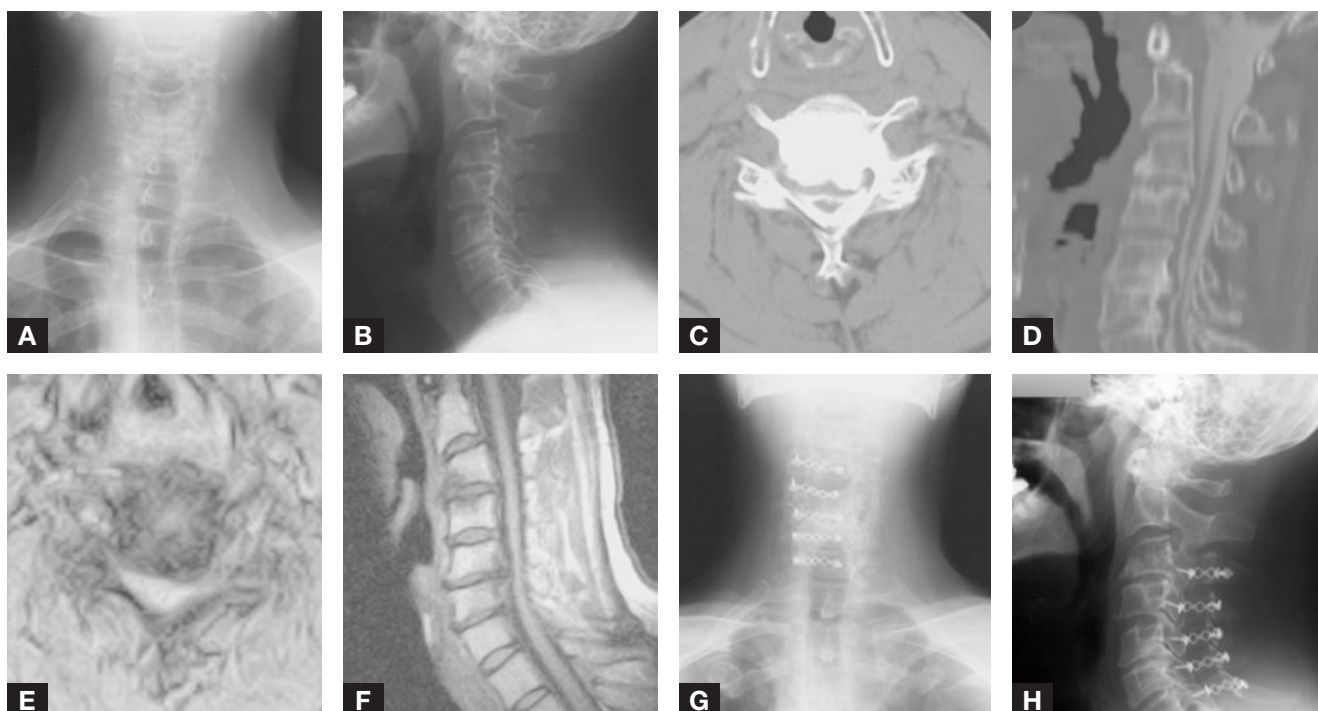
Fifty-nine-year-old man complained of neck pain and bilateral arm numbness and tingling, worse on left than on right. Positive Hoffmann and Babinski signs. Anteroposterior (A) and lateral (B) radiographs show spondylosis and degenerative changes in spine with maintenance of cervical lordosis. (C) Computed tomography (CT) shows narrowed spinal canal diameter. (D) Sagittal reconstruction of CT scan shows stenosis at several levels causing indentation of thecal sac. (E) Axial magnetic resonance imaging (MRI) shows narrowed spinal canal. (F) Sagittal MRI shows multilevel stenosis. Postoperative anteroposterior (G) and lateral (H) radiographs show instrumentation in place.
